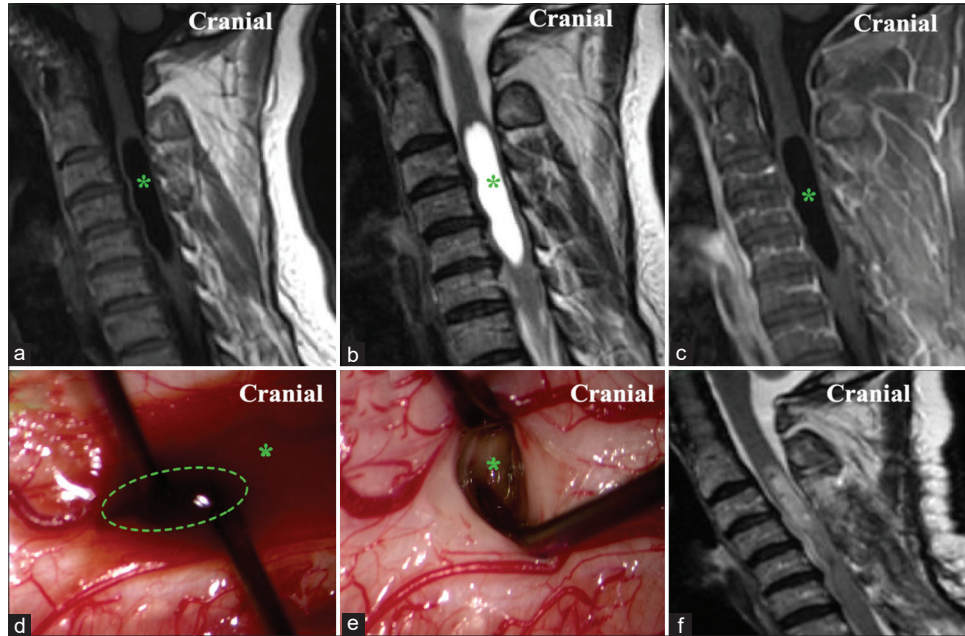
(a) Preoperative MRI T1 sequence of the cervical spine (sagittal view) shows a cystic lesion involving the cervical spinal cord (*). (b) Preoperative MRI T2 sequence of the cervical spine (sagittal view) shows a cystic lesion involving the cervical spinal cord (*). (c) Preoperative MRI T1 sequence with contrast of the cervical spine (sagittal view) shows a cystic lesion involving the cervical spinal cord (*). (d) Intraoperative image ($\times 50$) shows the midline myelotomy (*) to decompress the cyst. (e) Intraoperative image ($\times 50$) shows the old liquified hematoma emerging from the myelotomy (*). (f) Postoperative MRI T2 sequence of the cervical spine (sagittal view) shows the spinal cord after decompression of the intramedullary hematoma (*).
